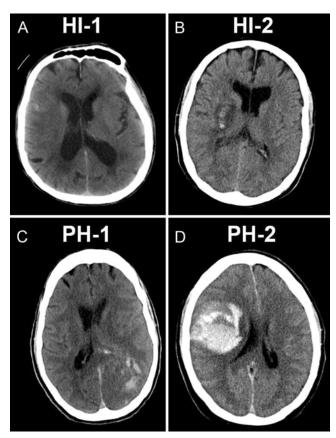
Noncontrast CT scans showing examples of radiographic types of revascularization-induced ICH, according to the ECASS classification. A: Right MCA stroke with small petechial hemorrhage representing hemorrhagic infarction Type 1 (HI-1). B: Right internal capsule stroke with larger confluent petechial hemorrhages within the infarct core representing HI-2. C: Left parietooccipital stroke with hemorrhage in less than 30% of the infarcted area and some mild space-occupying effect representing parenchymal hematoma Type 1 (PH-1) hemorrhage. D: A large hematoma with significant space-occupying effect is characteristic of PH-2 hemorrhage.
